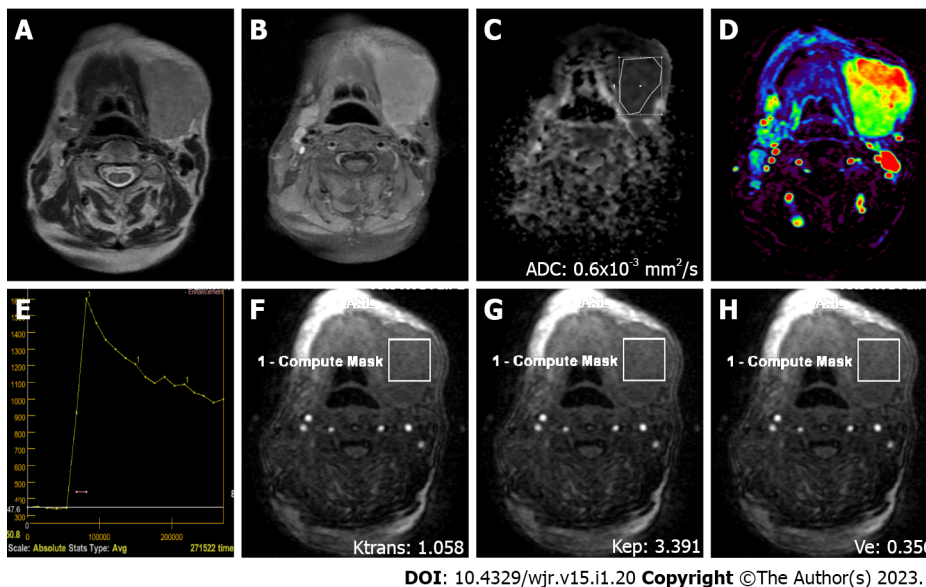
A 76-year-old female patient with diffuse large B cell lymphoma and a mass in the left submandibular gland region. A: On axial T2-weighted image, a smooth-contoured mass with homogeneous internal structure and an intensity similar to that of the submandibular gland is observed; B: Axial contrast-enhanced image shows the intense homogeneous contrast enhancement of the mass; C: On the apparent coefficient mapping image, the mass features prominent diffusion restriction (ADC value: $0.6 \times 10^{-3} \text{ mm}^2/\text{s}$); D: The mass is hyperperfused on color coded perfusion image; E: Type B time intensity curve shows a 48% washout ratio; F, G, and H: K_{trans} , K_{ep} , and V_e values on quantitative perfusion images were 1.058 min^{-1} , 3.391 min^{-1} , and 0.356, respectively. ADC: Apparent diffusion coefficient.
